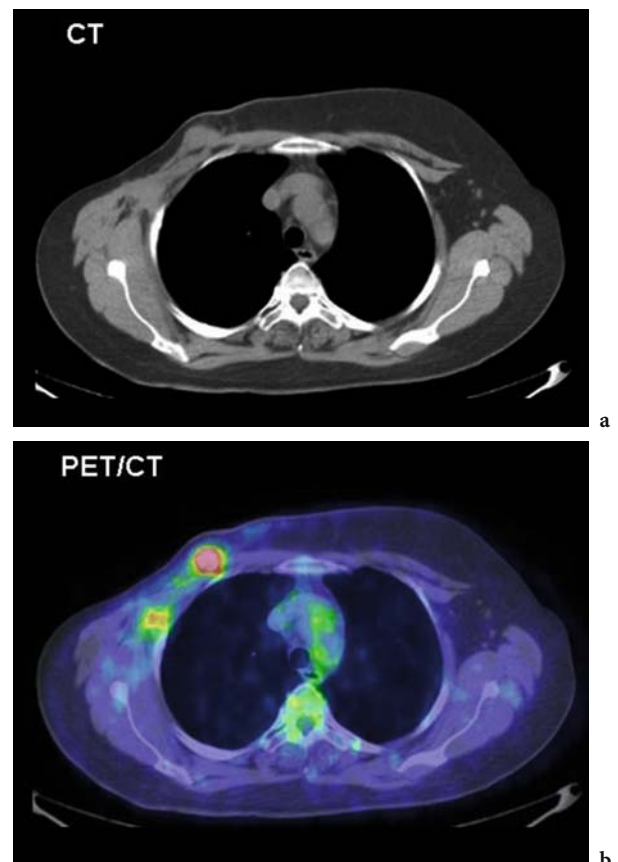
Patient surgically treated for breast cancer: recurrences in the left mammary region were detected by PET/CT during follow-up
